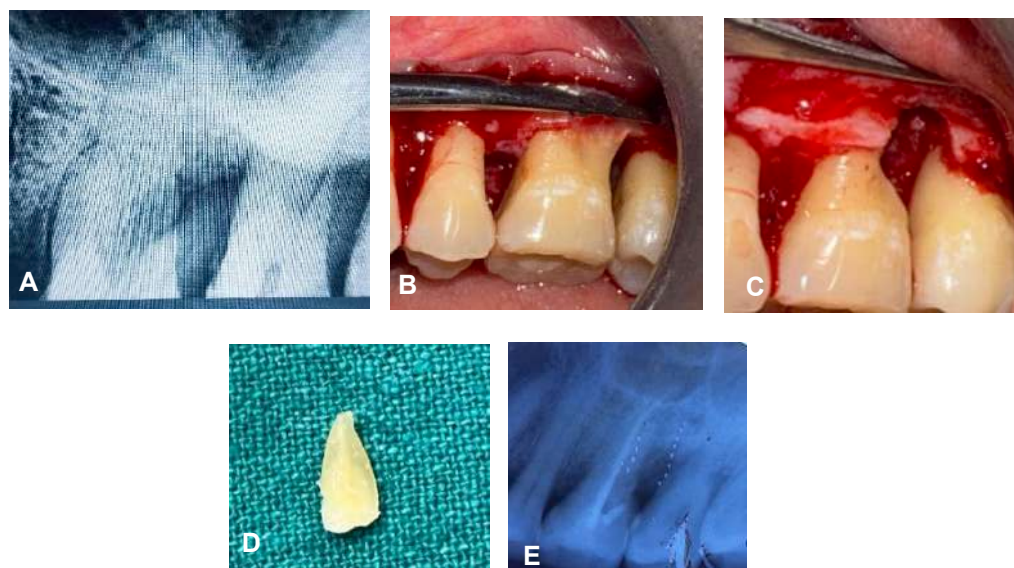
A- Case II Pre-operative radiograph B-After mucoperiosteal elevation C- Resection of distal root D- Resected distal root E-Healing after 1 year
